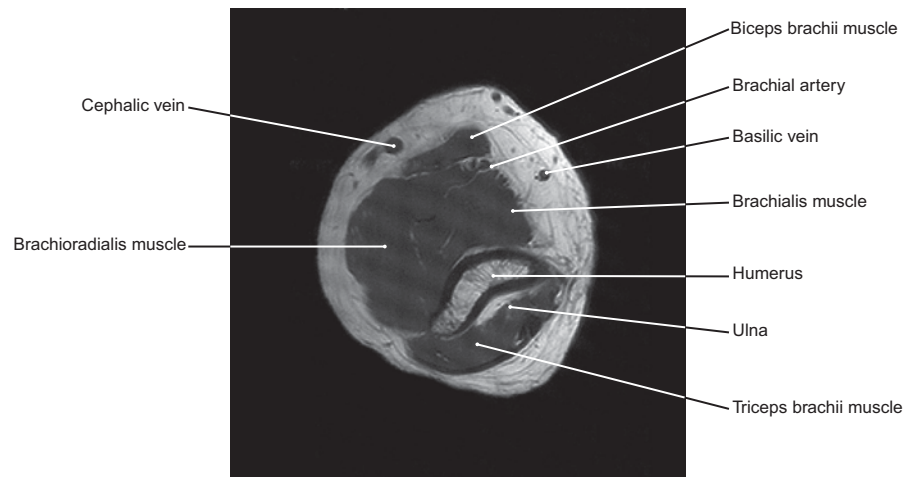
Magnetic Resonance Image (MRI). Cross Section at the Lower Third of the Arm
